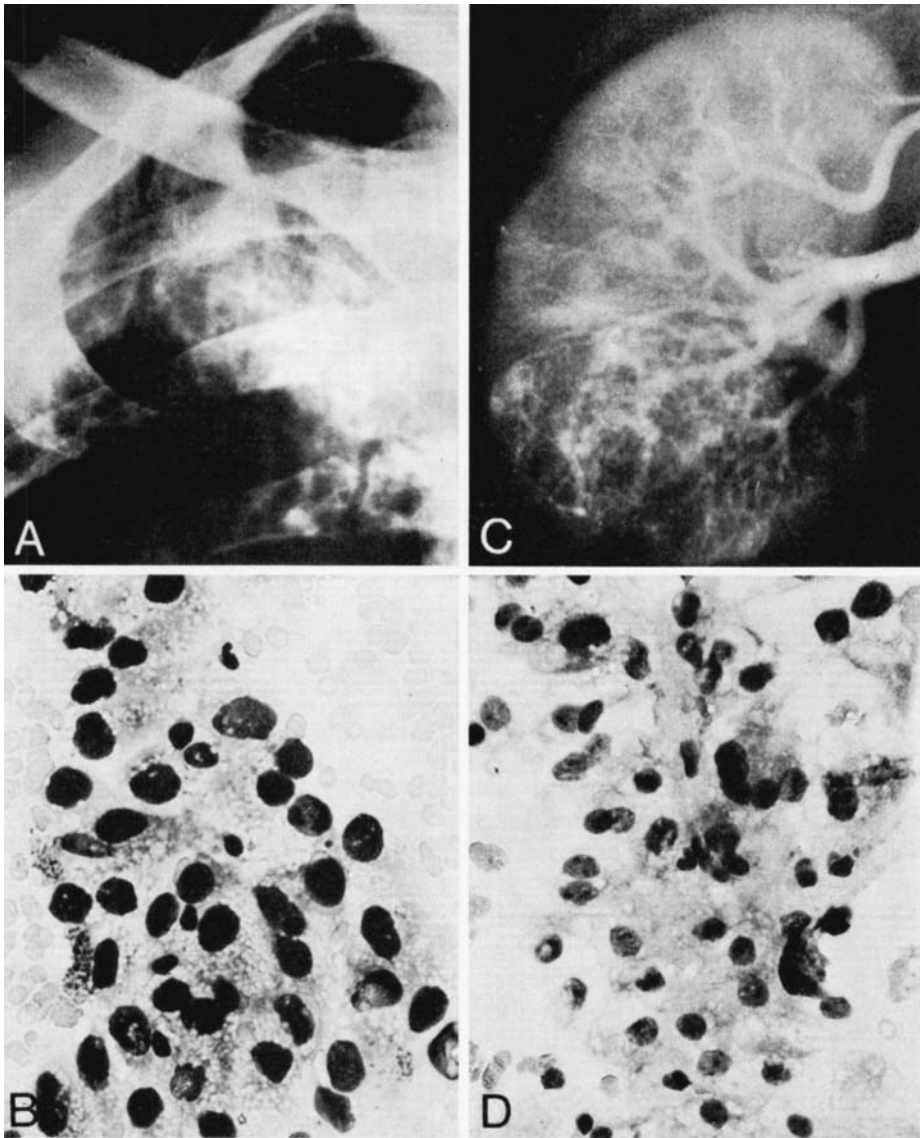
70-year-old man with pain in the right first rib. A. X-ray showed expansile osteolytic lesion in the right first rib suggesting chondroma or chondrosarcoma. B. Aspiration biopsy from the lesion in the first rib revealed hypernephroma cells. C. Angiography 1 week later showed malignant tumour in the right kidney. D. Aspiration from the renal lesion showed hypernephroma cells. Operation confirmed the diagnosis.
